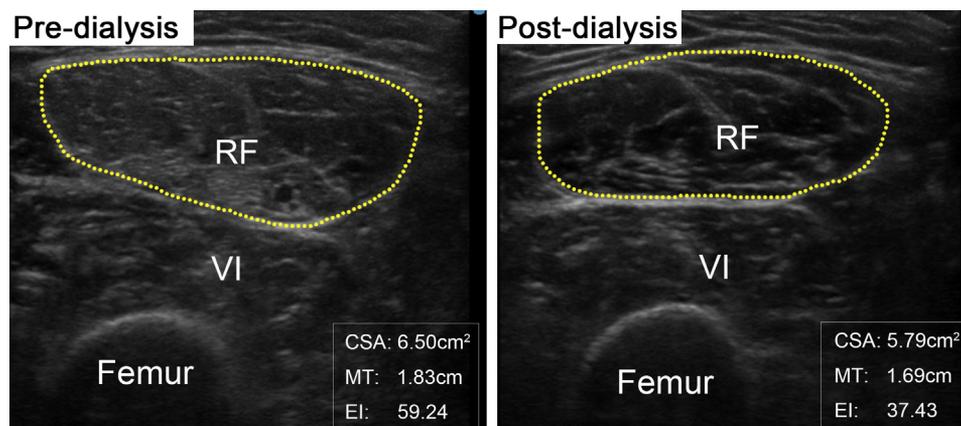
Representative comparison ultrasound images of predialysis and postdialysis obtained from the same rectus femoris location of one of the patients. The patient was 36 years old, male, and with a 7-year dialysis duration. Rectus femoris cross-sectional area is outlined by dotted line. The CSA, MT, and EI values of each image are marked at the lower right corner of the image. CSA, cross-sectional area; EI, echo intensity; MT, muscle thickness; RF, rectus femoris; VI, vastus intermedius.
